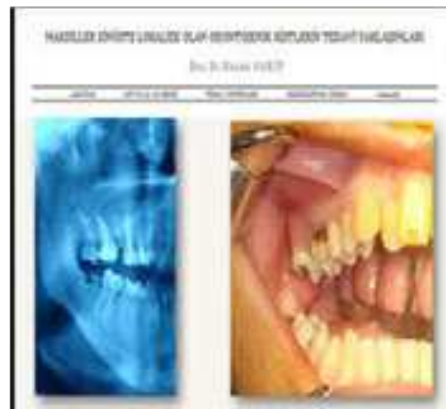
Radiological (OPG and CT) and intraoral clinical views.
